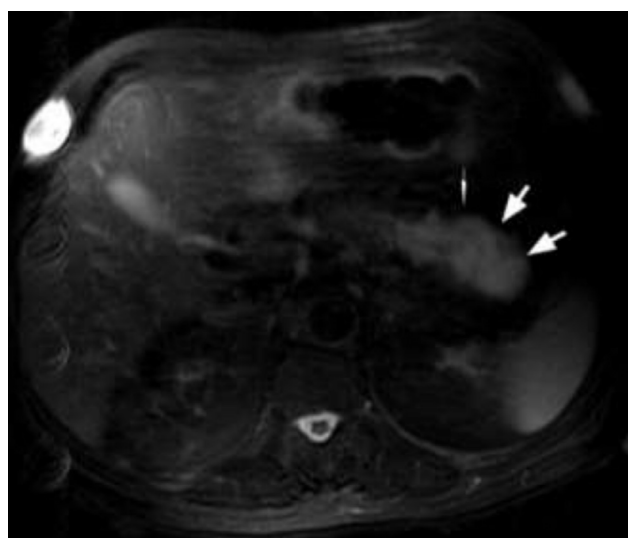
Axial T2 weighted fat saturated MR image obtained in June 2011 shows a T2 hyperintense mass causing fusiform dilation of the main pancreatic duct in the body and tail (arrows), confirming the CT findings.
